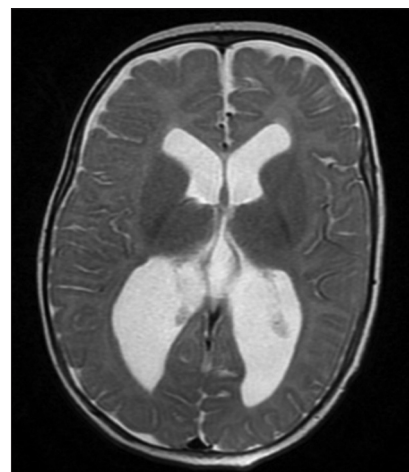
Magnetic resonance imaging brain image showing hydrocephalus
